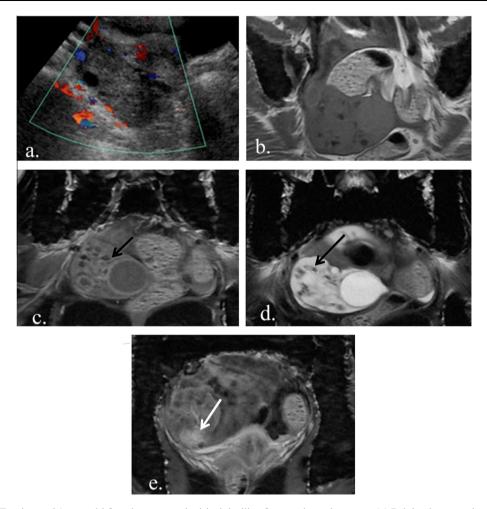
Ovarian Torsion: a 24 year old female presented with right iliac fossa pain and nausea. (a) Pelvic ultrasound revealed an enlarged right ovary with few peripherally situated follicles. No intra-ovarian vascularity was detected by color Doppler US. The patient had history of previous left sided oophorectomy for left ovarian torsion. (b, c &d) axial T1, axial T1 fat sat and axial T2 weighted images revealed an enlarged right ovary (black arrows) that shows small hypointense foci on both T1 and T2 weighted images most likely hemorrhagic, with a well defined non hemorrhagic cyst seen at its medial aspect. A rim of free fluid is seen surrounding the ovary on T2 weighted image. (e) Axial T1 post contrast image shows minimal enhancement (white arrow) likely minimal supply at its capsular layer. A note was made of the diffuse marrow hypointense signal at all pulse sequences (known hemolytic anemia patient).
